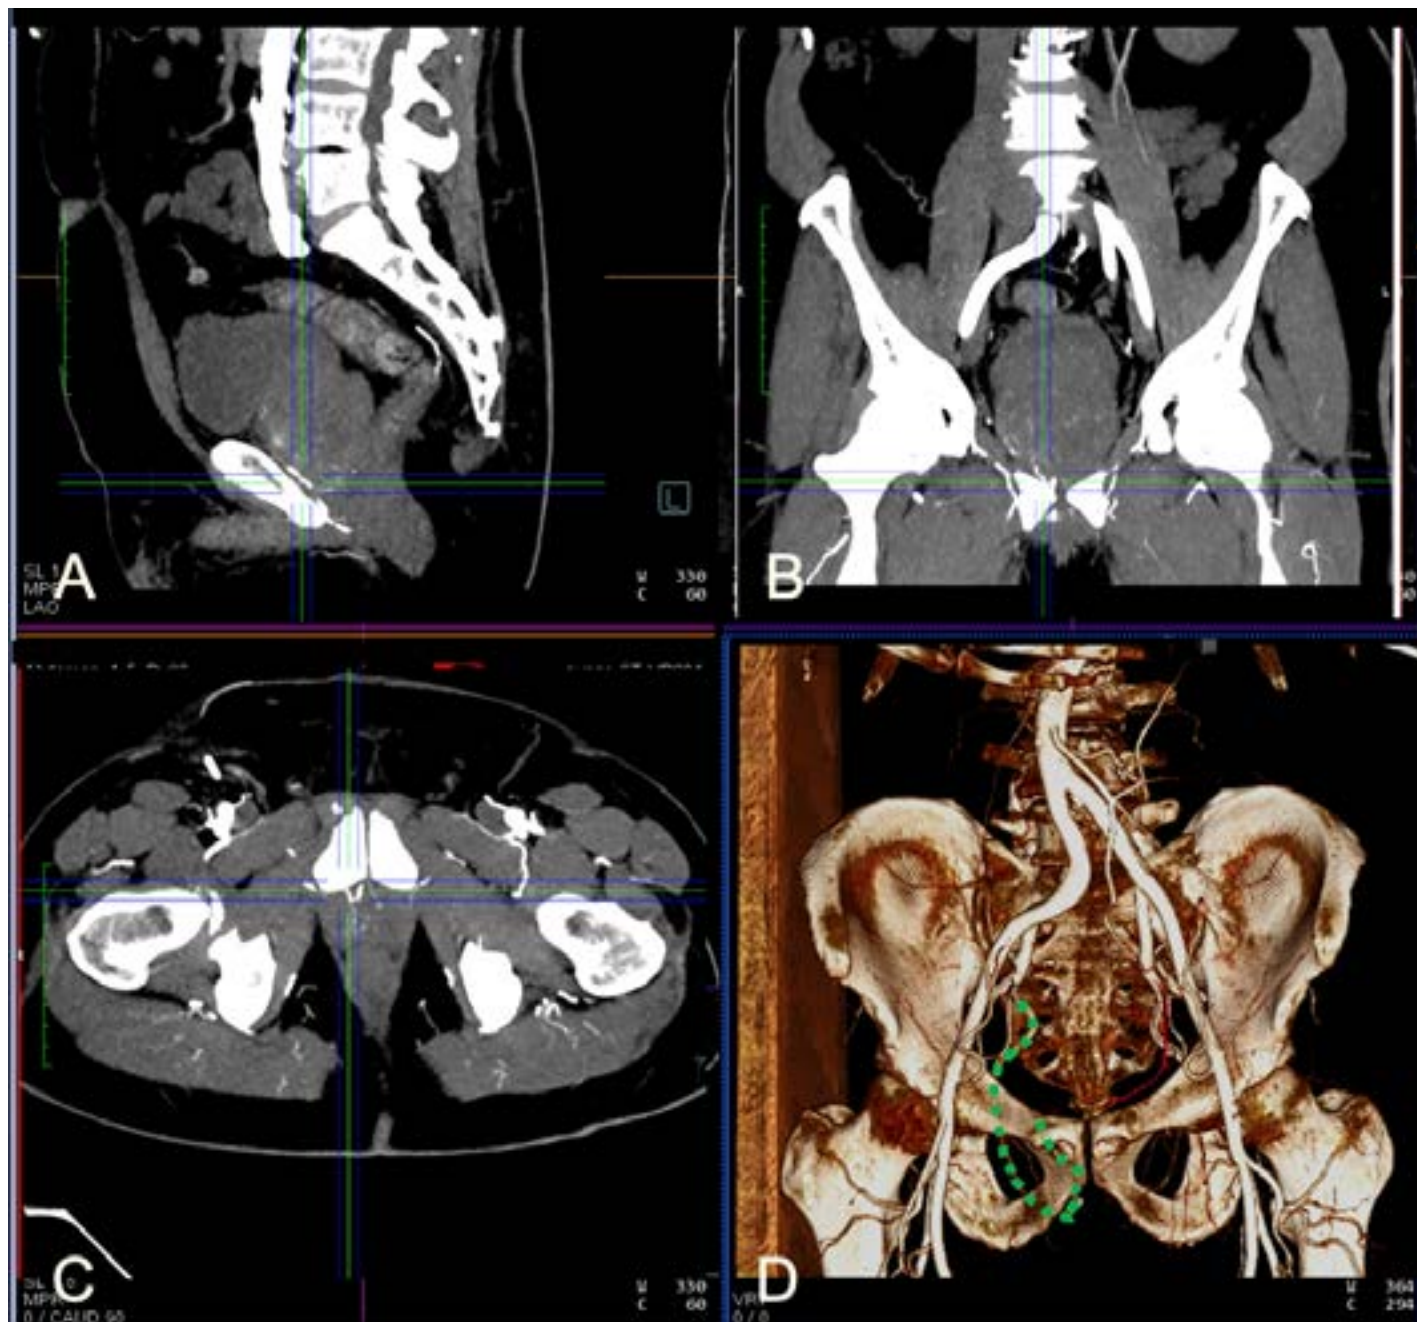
Multiplanar images (A) Saggital (B) Coronal (C) Axial, and (D) Emboguide reconstruction from intra-procedural CTA demonstrating reperfusion of the prostate through distal internal pudendal collateral (green-dash).
